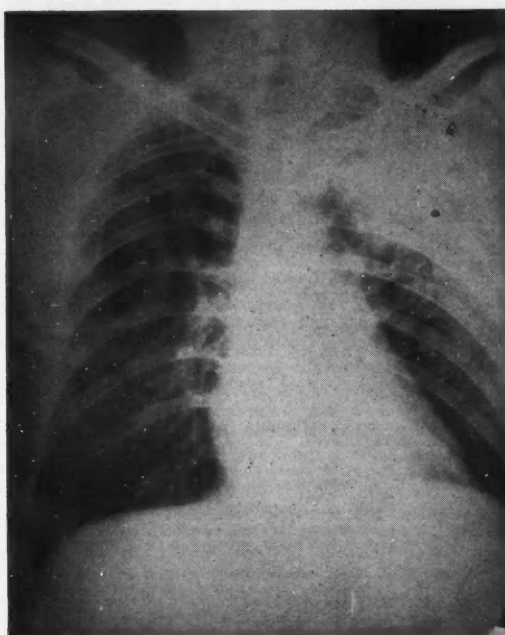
X-ray of the lungs taken May 29, 1945 (date of admission).
